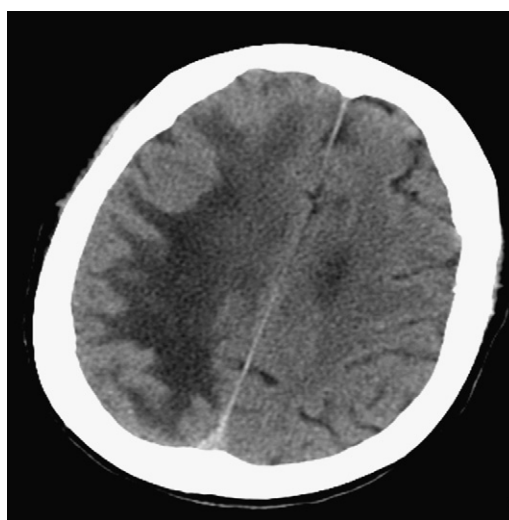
Progressive multifocal leukoencephalopathy (PML). Noncontrast head CT demonstrates extensive abnormal low attenuation within the right frontal and parietal lobes.
